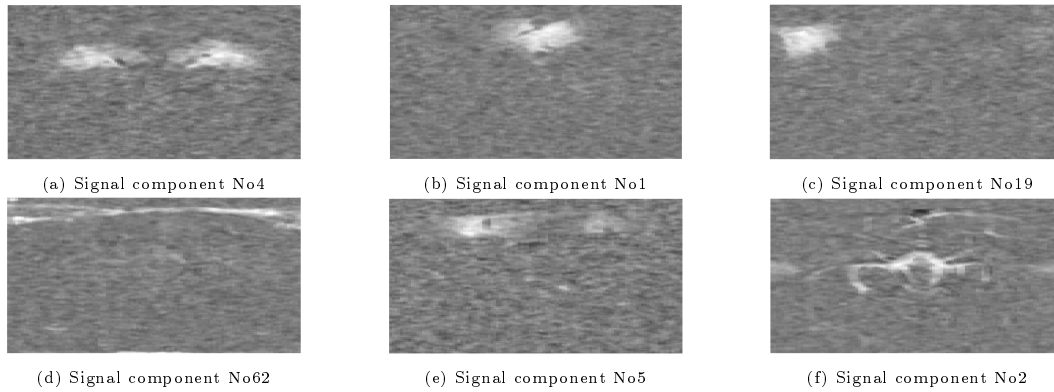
Presentation of the six spatial signal components (numbered according to the set of 100 reference components of dataset 14_30_03, Appendix Figures 1 - 5) with the largest number of activation frames during the dynamic analysis of the five functional ultrasound datasets.
